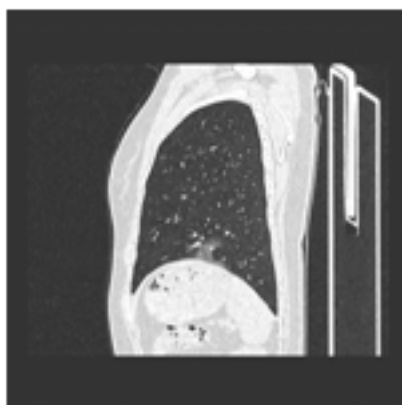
A chest CT of patient named WHM who was tested positive for new coronavirus nucleic acid.
